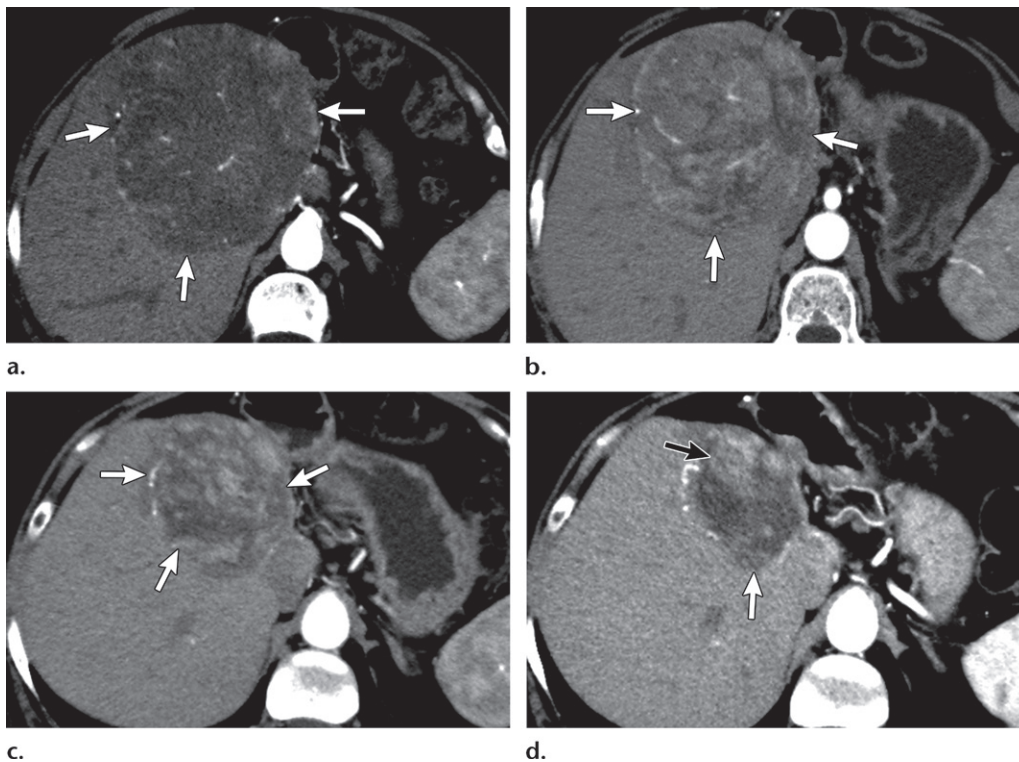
Axial arterial phase CT findings before and after TARE in a 67-year-old woman who had cirrhosis and HCC. (a) Contrast material-enhanced pretreatment image shows HCC (arrows) in liver segments IV, VII, and VIII. (b) Image obtained 45 days after treatment shows the lesion (arrows) with a stable size and persistent enhancement. (c, d) Images obtained 3 months (c) and 6 months (d) after treatment show a progressive reduction in tumor size and partial devascularization of the lesion (white arrows), with residual enhancement (black arrow in d) in the anterior sector.
